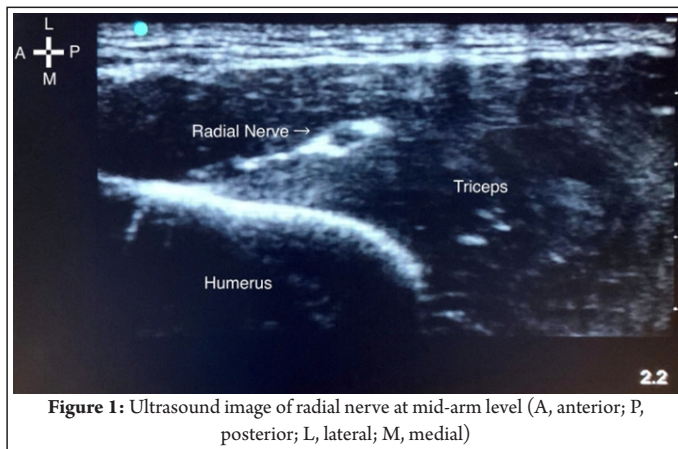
Ultrasound image of radial nerve at mid-arm level (A, anterior; P, posterior; L, lateral; M, medial)
